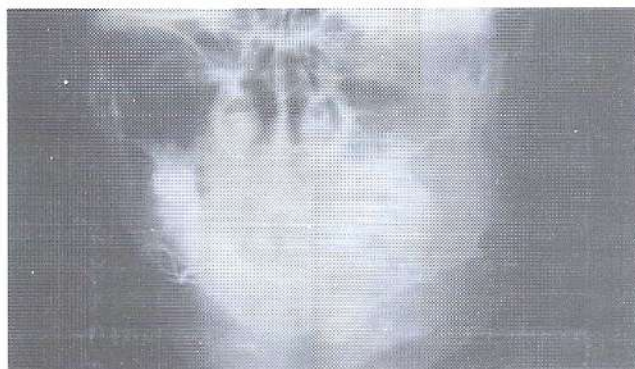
PA radiograph showed the placement of direct wiring and lower border wiring (figure eight).
